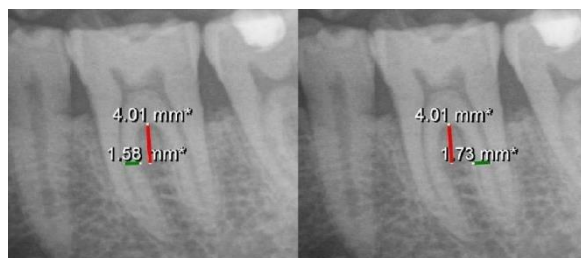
Measurement of mesial (left) and distal (right) dentin thicknesses on panoramic radiography 4 mm below furcation.
